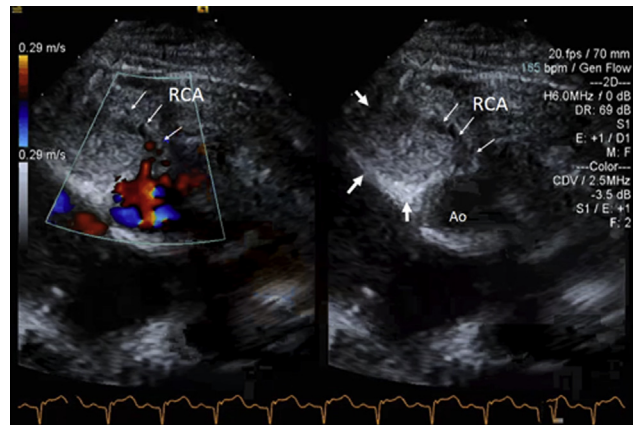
Short-axis imaging at the level of the aortic root demonstrates the RCA, which appears to be compressed by the large hyper-echoic mass (*large arrows*) with anterograde flow in the coronary artery documented by color Doppler (*small arrows*). *Ao*, Aorta.
